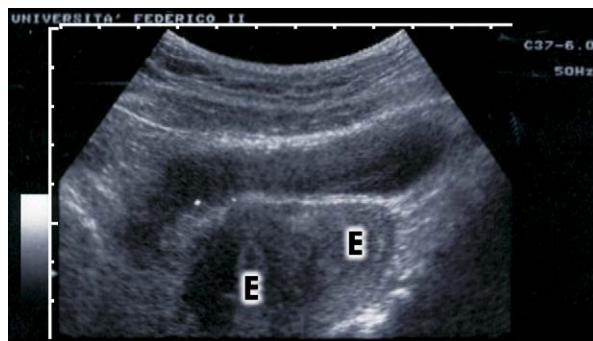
Transabdominal ultrasonography (E = endometrium).
